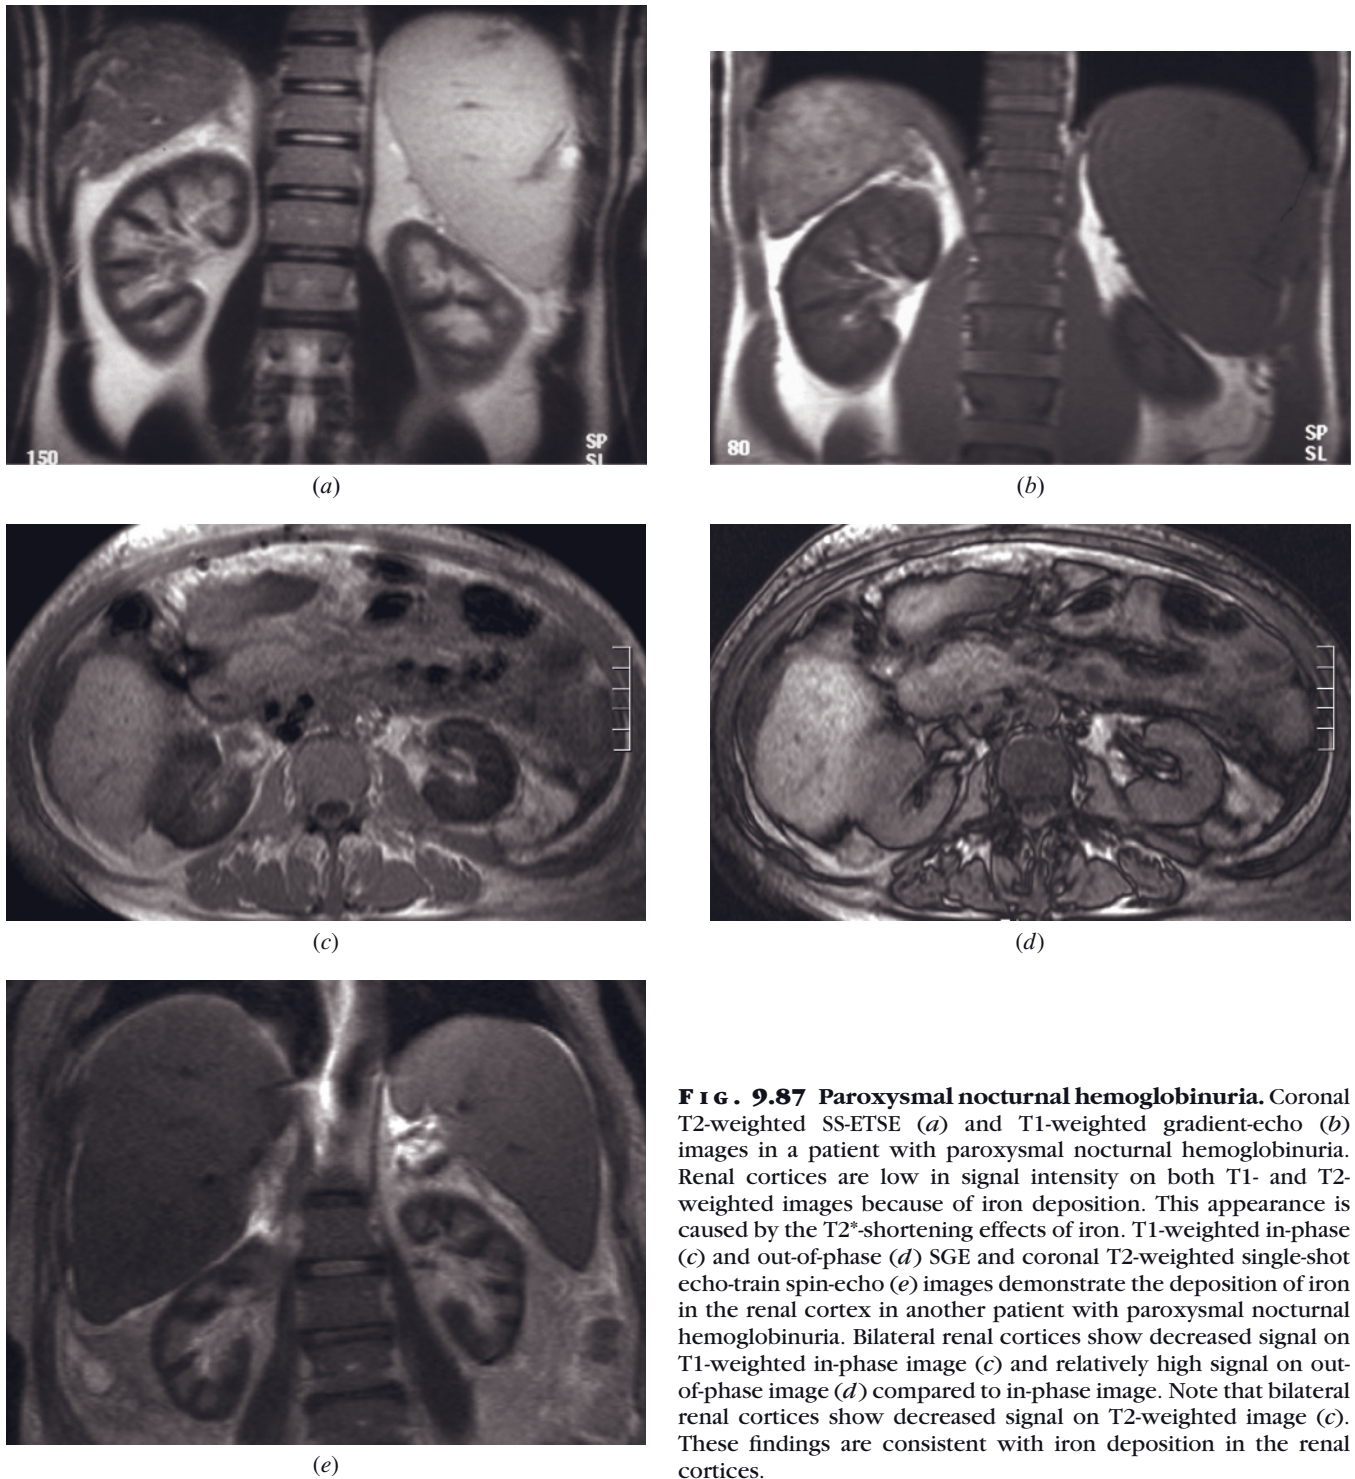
Paroxysmal nocturnal hemoglobinuria. Coronal T2-weighted SS-ETSE (a) and T1-weighted gradient-echo (b) images in a patient with paroxysmal nocturnal hemoglobinuria. Renal cortices are low in signal intensity on both T1- and T2-weighted images because of iron deposition. This appearance is caused by the T2*-shortening effects of iron. T1-weighted in-phase (c) and out-of-phase (d) SGE and coronal T2-weighted single-shot echo-train spin-echo (e) images demonstrate the deposition of iron in the renal cortex in another patient with paroxysmal nocturnal hemoglobinuria. Bilateral renal cortices show decreased signal on T1-weighted in-phase image (c) and relatively high signal on out-of-phase image (d) compared to in-phase image. Note that bilateral renal cortices show decreased signal on T2-weighted image (c). These findings are consistent with iron deposition in the renal cortices.
